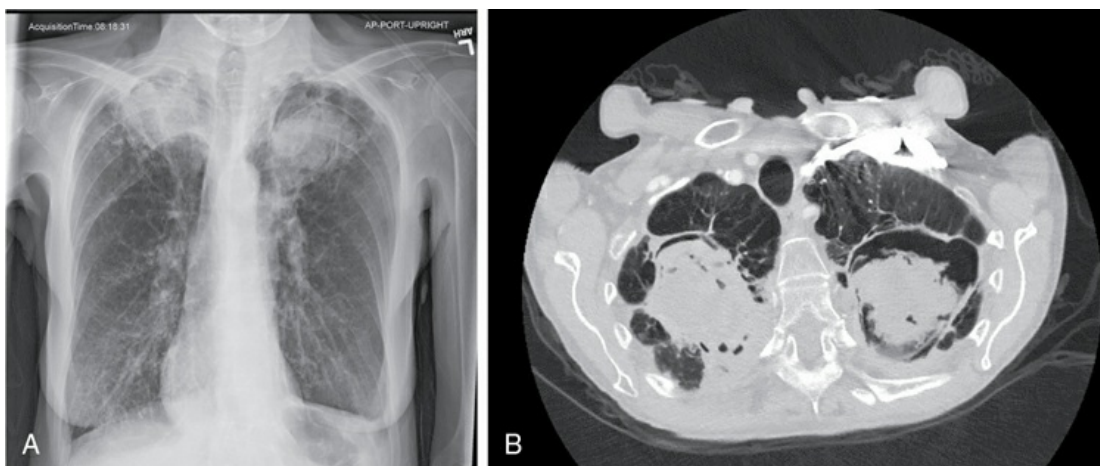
Posteroanterior radiograph (A) and axial chest CT section (B) show bilateral upper lobe aspergillomas. Each fungus
